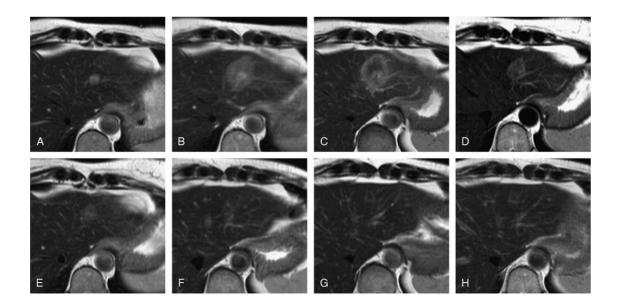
MRI evolution of the lesion after IRE (imaging from Barbarasch et al.). (A) Lesion pre-IRE. (B-D) Appearance of the hyperintense rim in arterial phase still one week after the treatment. (E-H) Enhancement of the lesion slowly disappears till 1 year after the ablation (H) is not visible any more.
